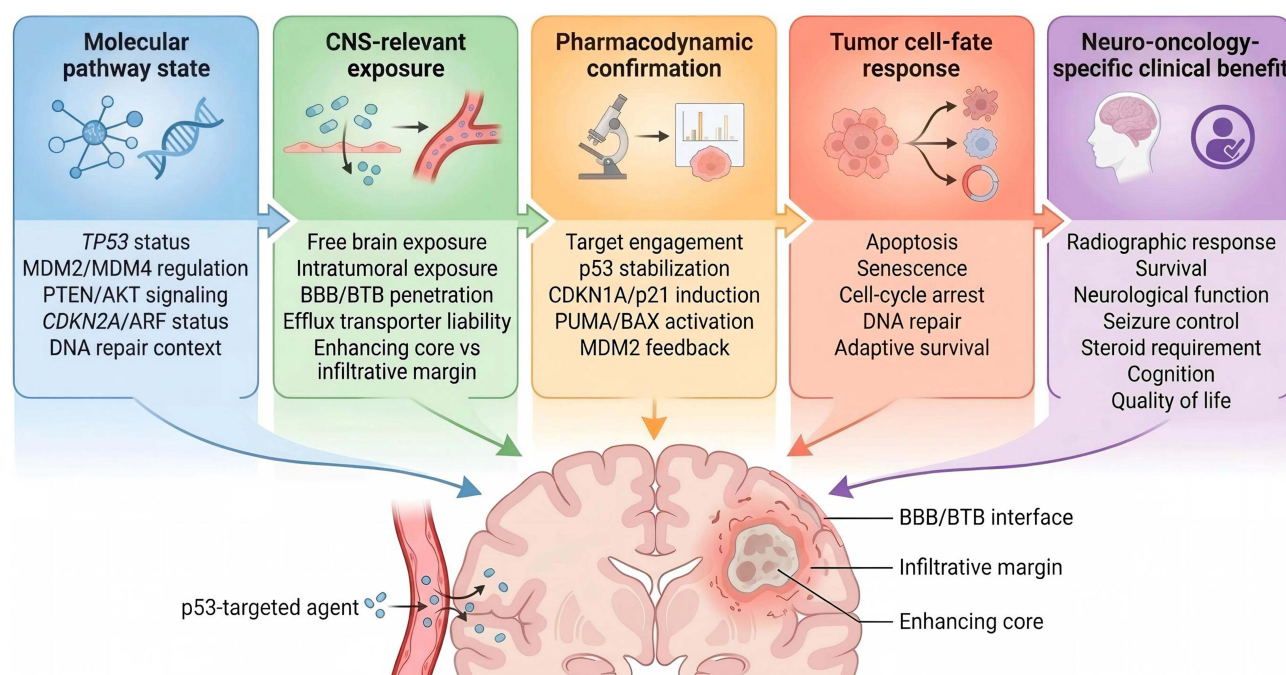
CNS-specific framework for p53 pathway-targeted therapy in glioblastoma. The proposed framework links molecular pathway state, CNS-relevant exposure, pharmacodynamic confirmation, tumor cell-fate response, and neuro-oncology-specific clinical benefit. TP53 status, MDM2/MDM4 regulation, PTEN/AKT signaling, CDKN2A/ARF status, DNA repair context, and downstream apoptotic competence collectively define therapeutic plausibility. Unbound brain exposure and intratumoral distribution determine whether a p53-targeted agent reaches the enhancing tumor core, the BBB/BTB interface, and the infiltrative margin. Pharmacodynamic markers establish whether pathway modulation occurs in tumor tissue and whether it results in apoptosis, senescence, cell-cycle arrest, DNA repair, or adaptive survival. Clinical translation should incorporate radiographic response, survival, neurological function, seizure control, corticosteroid requirement, cognition, and quality of life.
